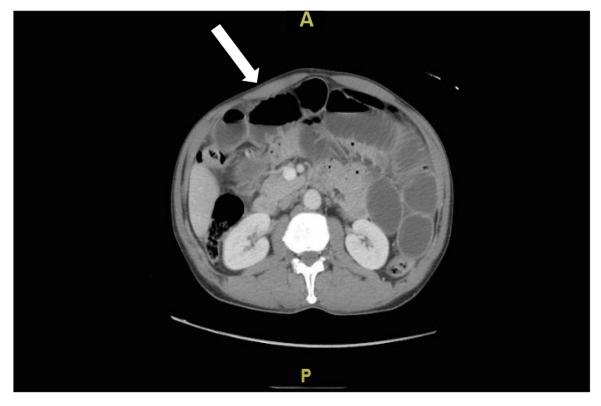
CT showing small bowel obstruction caused by the incarcerated right inguinal hernia, with fluid filled and dilated loops of small bowel.
